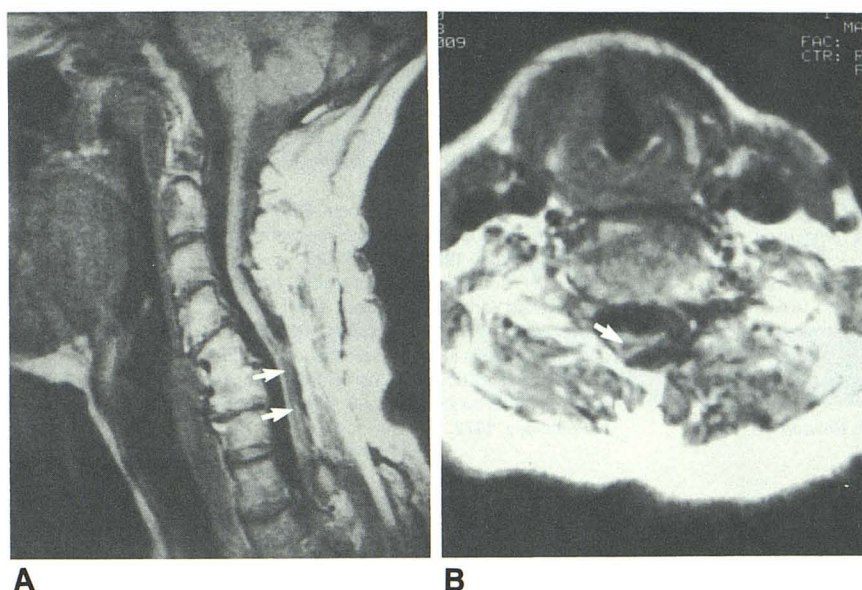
Myelomalacia in 53-year-old woman with a history of chronic posttraumatic myelopathy. Sagittal (A) and axial (B) T1-weighted spin-echo images (TR = 600 msec, TE = 25 msec) show an atrophic, misshapen, lower cervical cord associated with intramedullary zone of decreased signal intensity (arrows). Myelomalacia was confirmed by intraoperative sonography. Note solid C5–C6 anterior vertebral fusion and abnormal spinal curvature.
